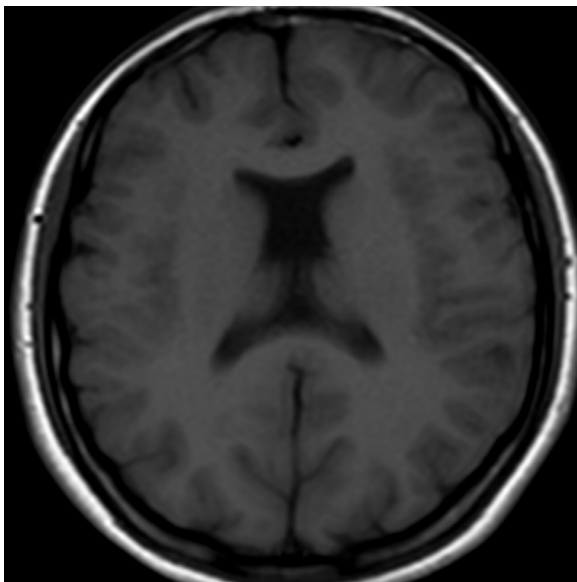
Axial T1 weighted MRI image at the level of basal ganglia showing the absence of septum pellucidum.
